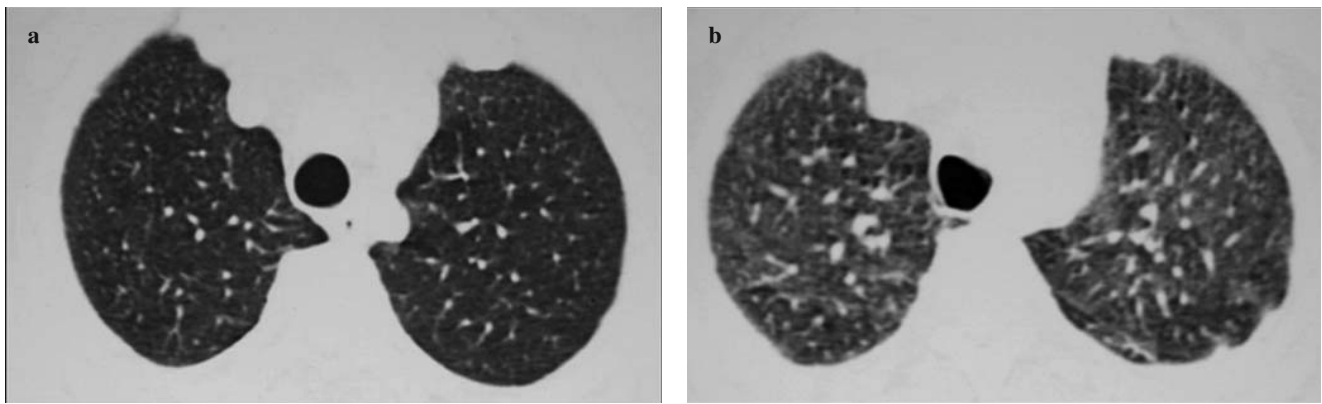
A 29-year-old nonsmoker, with no known previous lower respiratory tract disease. a On inspiratory high-resolution computed tomography (HRCT), no abnormal findings are seen in the upper lung fields; b on deep expiratory HRCT, areas of air trapping are demonstrated in a patchy and segmental distribution bilaterally.
